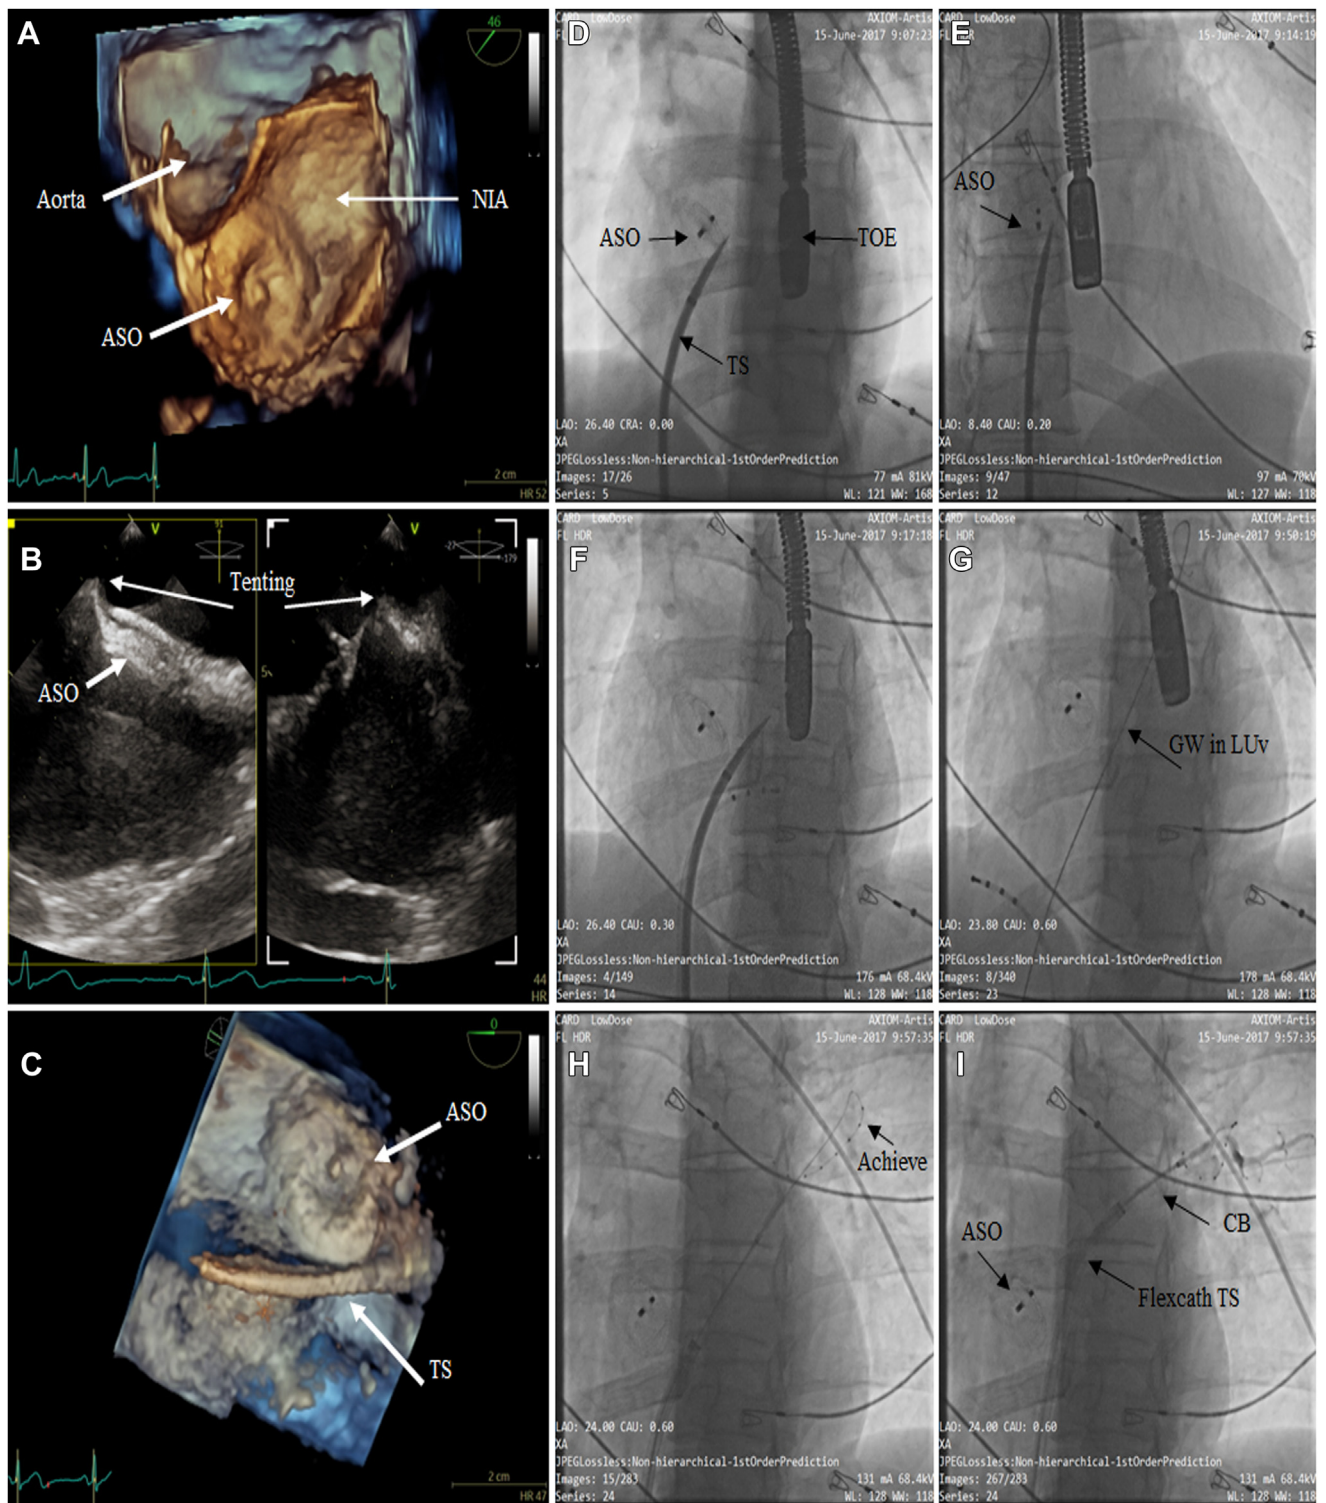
Posteroinferior transseptal puncture. A: Three-dimensional transesophageal echocardiography (TEE) reconstruction of native interatrial septum (NIA), aorta, and atrial septal occluder (ASO) showing not enough space anteriorly between the ASO and the aorta for the puncture. B: Two-dimensional X-plane images showing the needle tenting on the native septum below the ASO. C: Three-dimensional TEE reconstruction showing the 12F transseptal sheath (TS) posteroinferior to the ASO. D–G: Fluoroscopy images showing the TS puncture sequences. H, I: The multipolar catheter (Achieve; Medtronic Inc, Minneapolis, MN) in the left upper vein and the cryoballoon (CB) ablation catheter occluding the vein.
